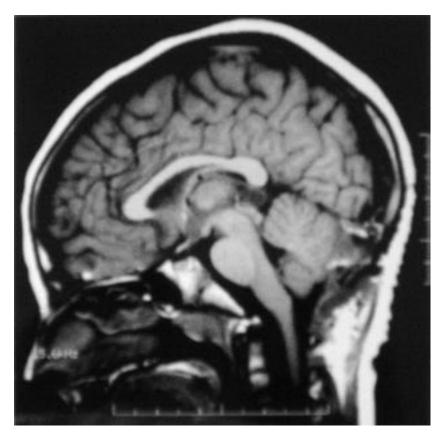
Preoperative sagittal T1-weighted magnetic resonance image of the brain demonstrating a 1 cm cystic lesion with mass effect on the pineal gland.
